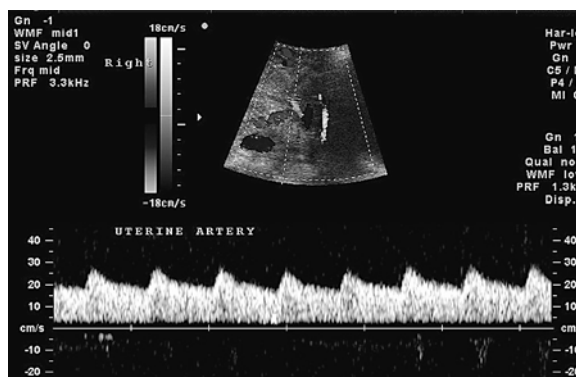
Normal uterine Doppler wave form at 24 weeks' gestation
